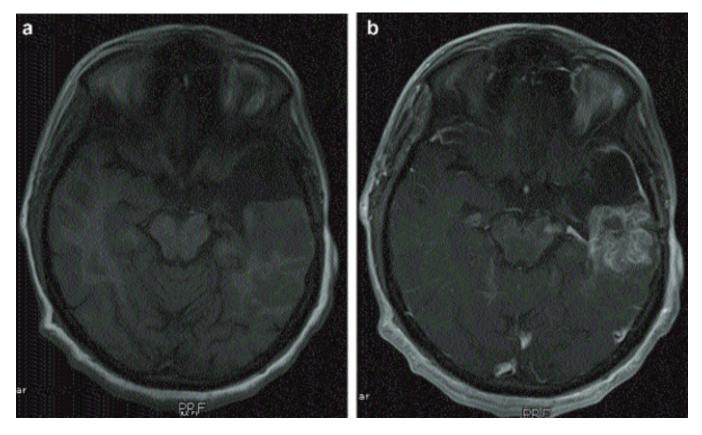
a, b) MRI T1WI pre and post contrast axial images showing a potentially resectable right temporal GBM.
